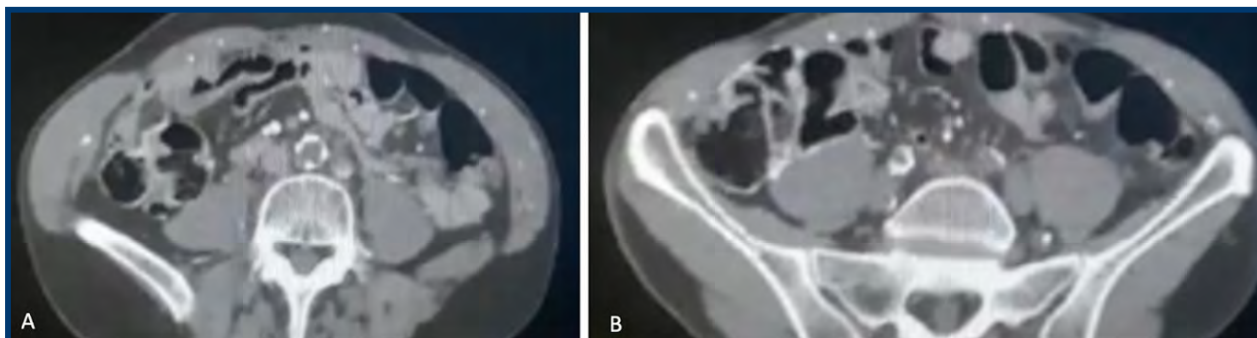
Thoracoabdominal-computed tomography angiography. Evidence of chronic complete occlusion of (A) the infrarenal aorta and aortic bifurcation and (B) involvement of the common iliac arteries.
